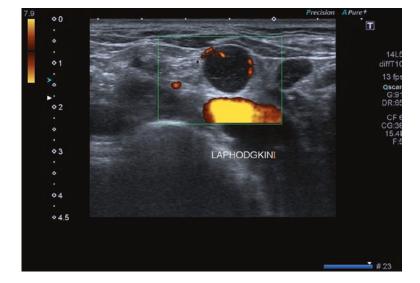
USG image of spherical lymphadenopathy (LAP) with hypoechoic cortex and an effaced hilum in a Hodgkin lymphoma (HL) case. Peripheral vascularization is seen on color Doppler USG
